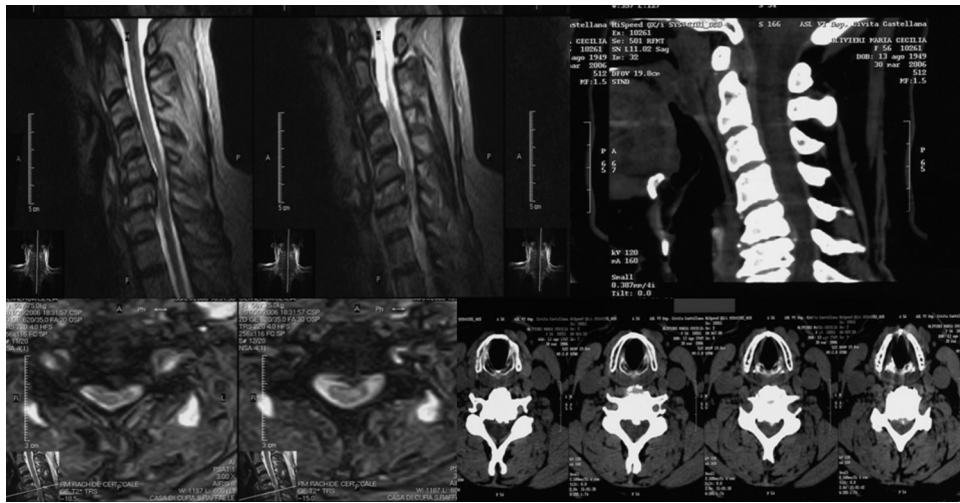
MR sagittal T2 W (left upper) and axial (left lower) and CT scan (right upper) and axial (right lower) showing a cervical spine MR along with CT scans showed a C5 and C6, C6 and C7 spinal canal stenosis with radiological sign of cervical myelopathy and impingement of CSF anterior film.
